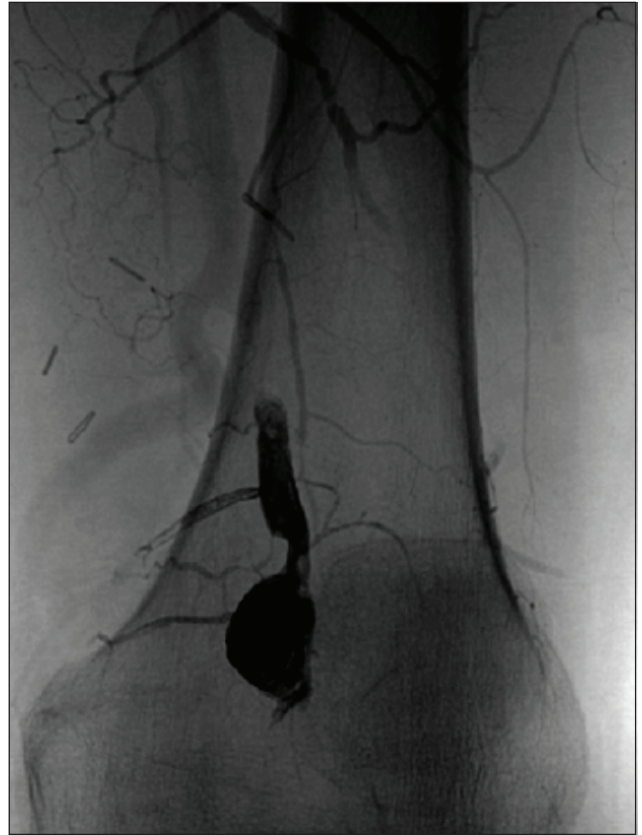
Late follow-up CT angiography showing radiopaque occlusive substance in the aneurysmal sac and the origin of genicular collateral branches.
